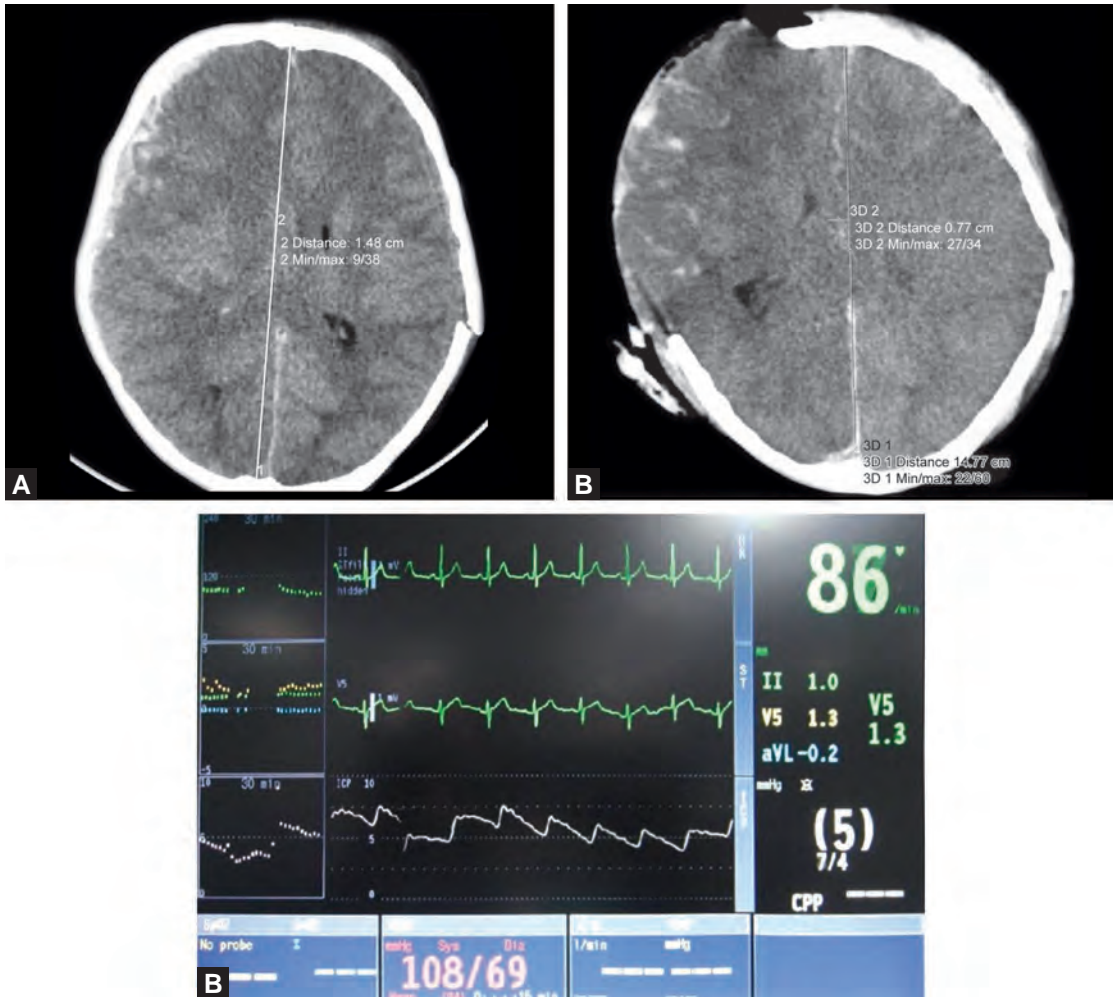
Non-contrast axial CT scan showing a crescentic acute subdural haematoma causing midline shift
